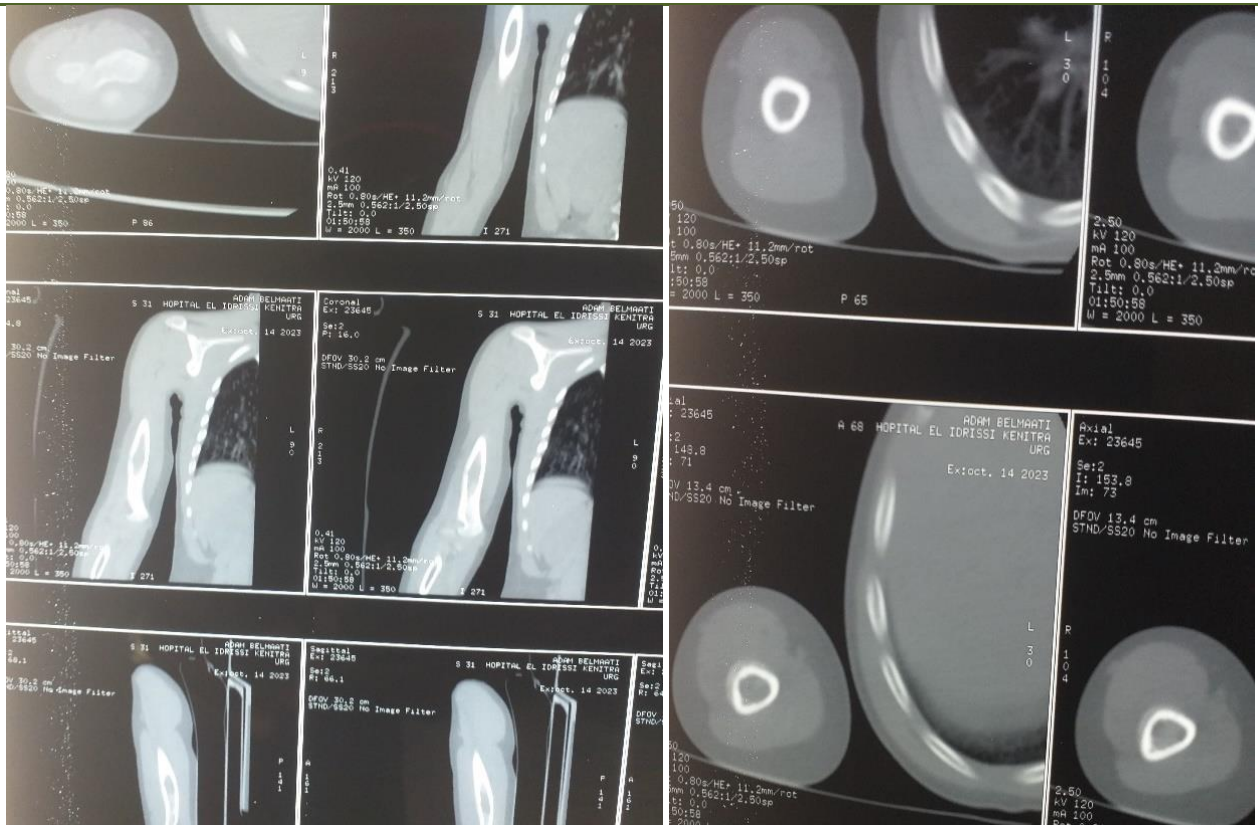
CT of the arm showed a mid-external diaphyseal cortical defect with unilamillary periosteal reaction
